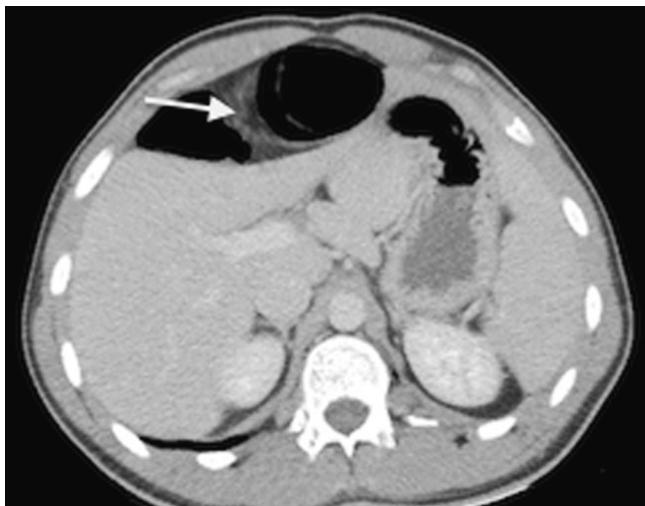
CT scannergram showing caecum lying in the left iliac fossa with volvulus of the colon in the right subdiaphragmatic space.
